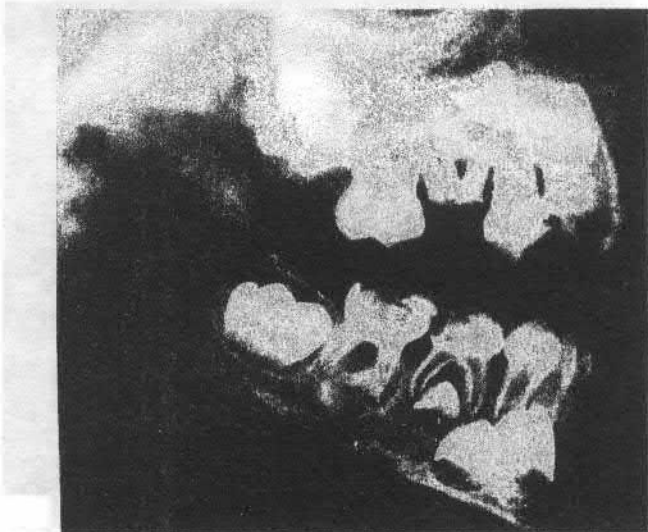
Radiography of maxillaries at the age of 9 months
